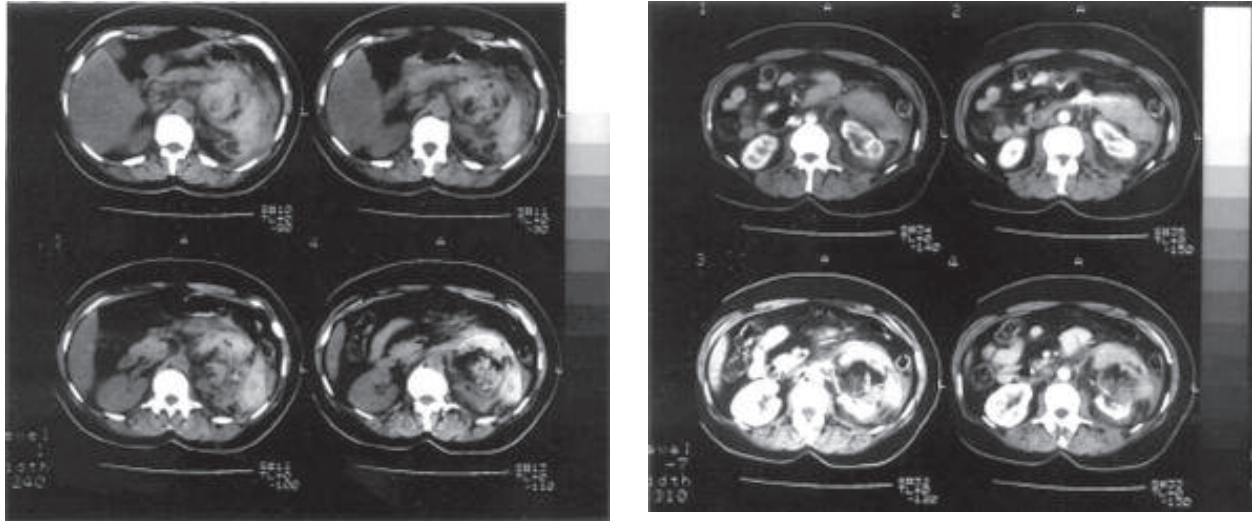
Precontrast (left panel) and postcontrast (right panel) section of abdominal CT showing extensive retroperitoneal hematoma originating from the upper pole of the left kidney.
